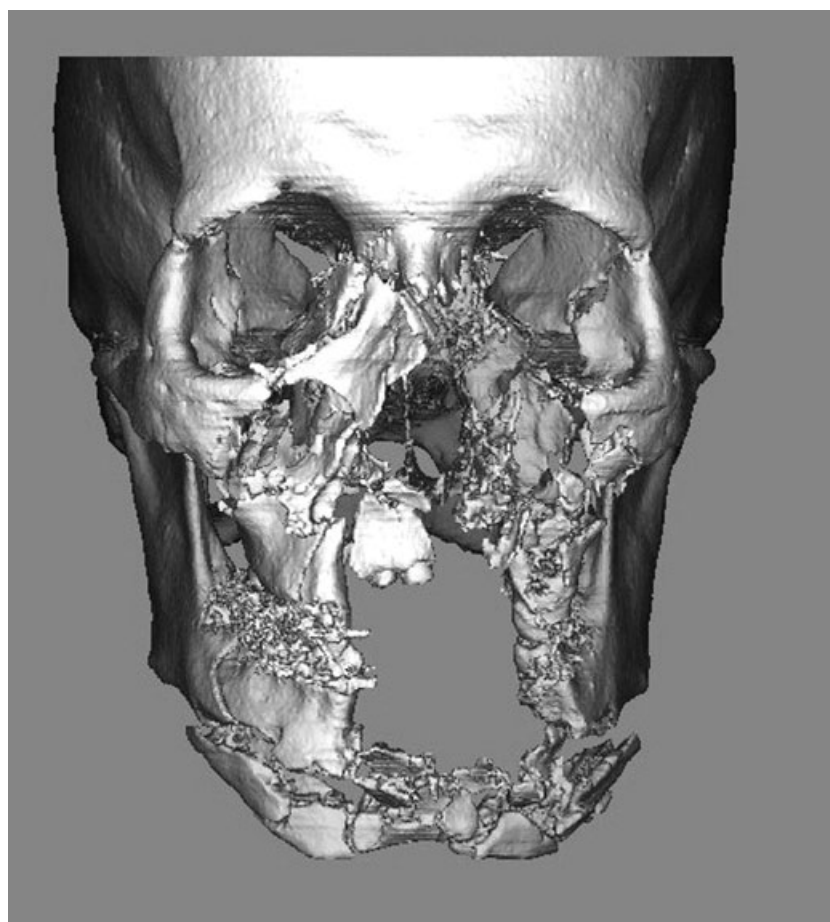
Reformatted CT scan of this patient's facial skeleton after the initial surgical procedures that included stabilization of the posterior segments. Note the significant loss of bone from the anterior maxilla and mandible, as well as the numerous comminuted mandibular segments.
